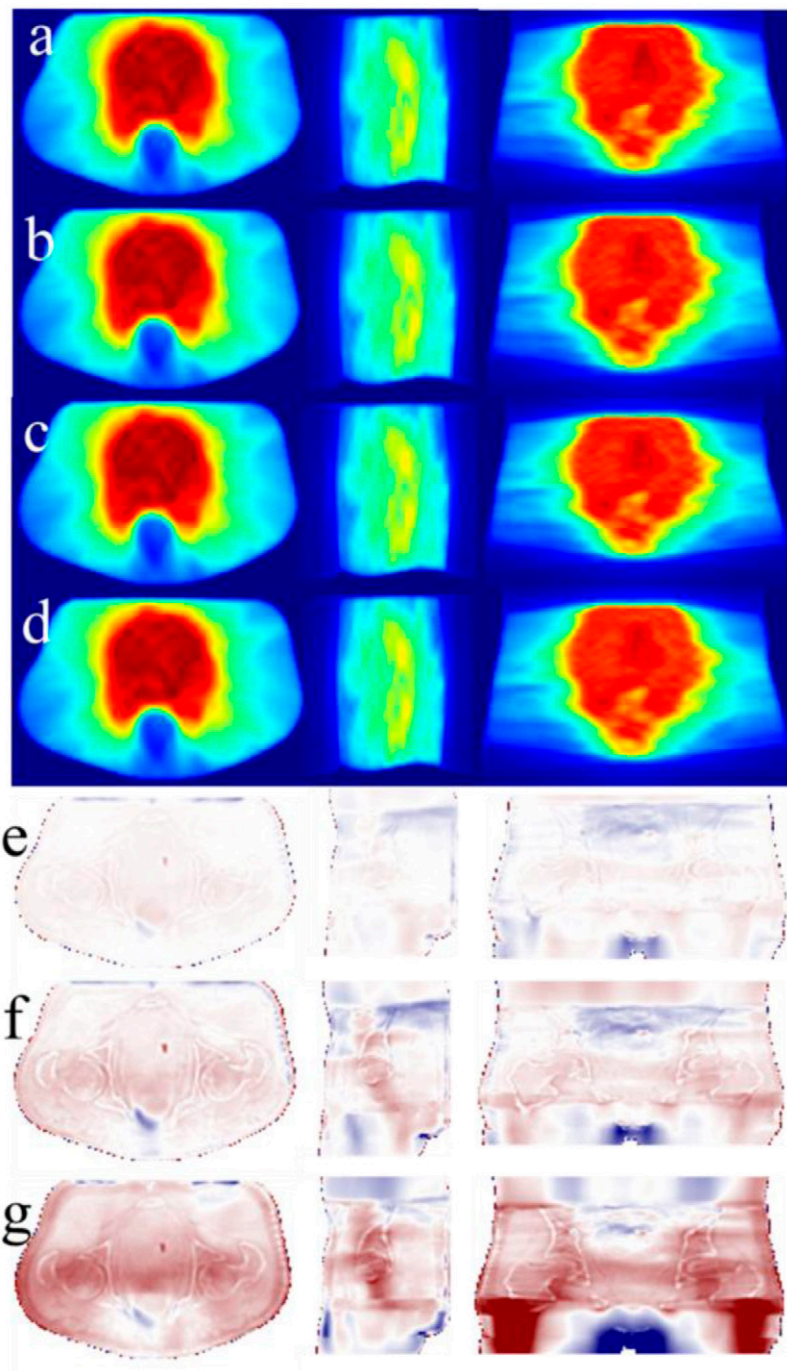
Representative slices of dose distributions calculated using (a) CT, (b) LW pseudo-CT, (c) MV pseudo-CT and (d) water-only. Dose distribution error maps are also shown: (e) LW, (f) MV and (g) water-only.
